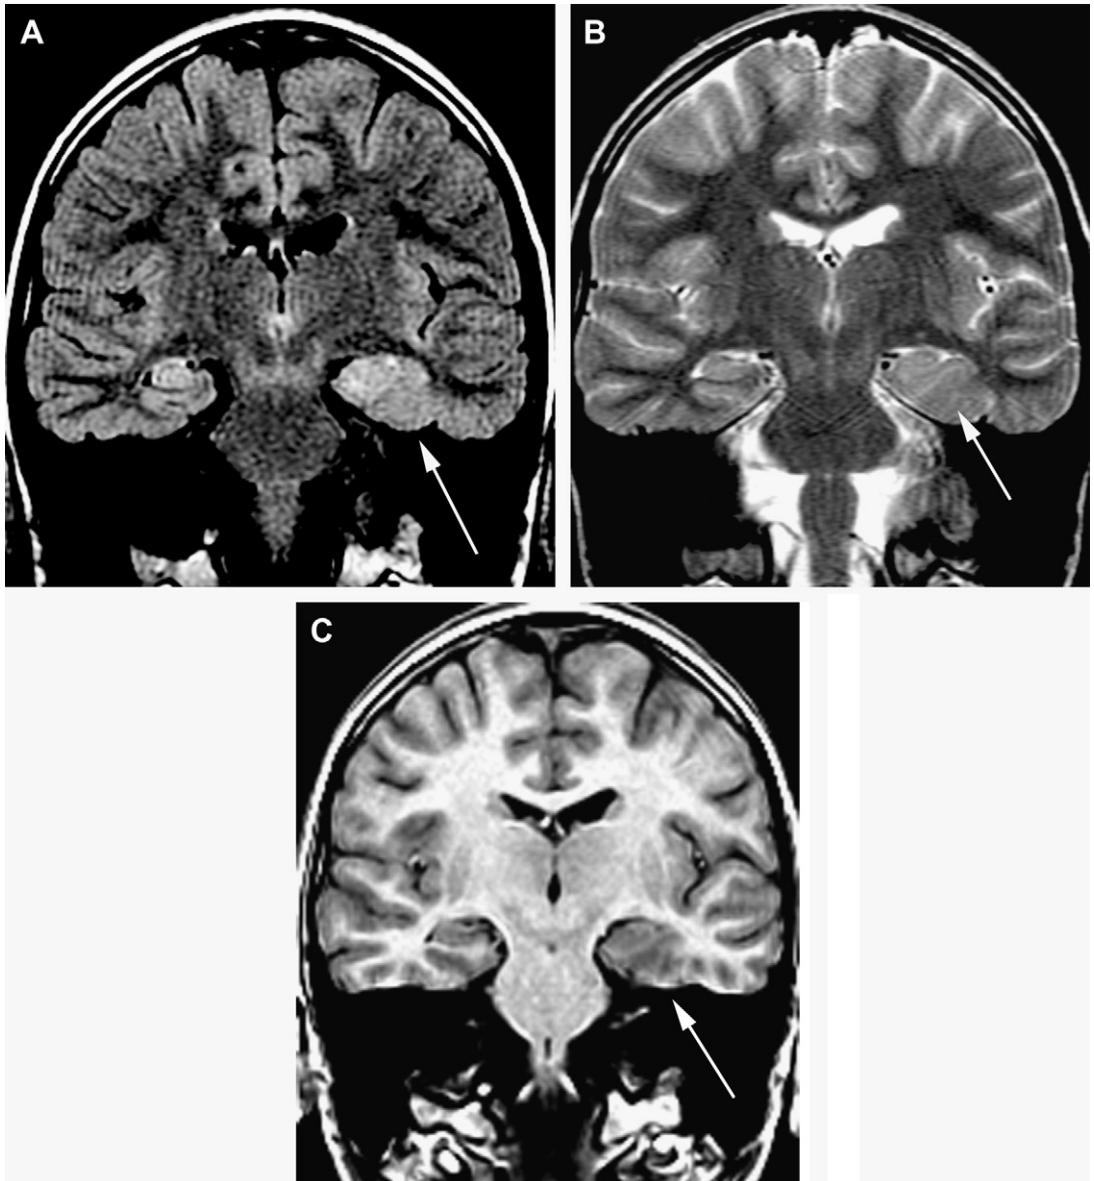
Cortical dysplasia with oligodendroglial hyperplasia. (A–C) FLAIR, T2, and T1 coronal imaging demonstrate swelling of the left mesial temporal lobe with increased T2/FLAIR and decreased T1 signals of both cortex and white matter (*arrow*). Pathology demonstrated infiltration by nonneoplastic oligodendrocytes.
